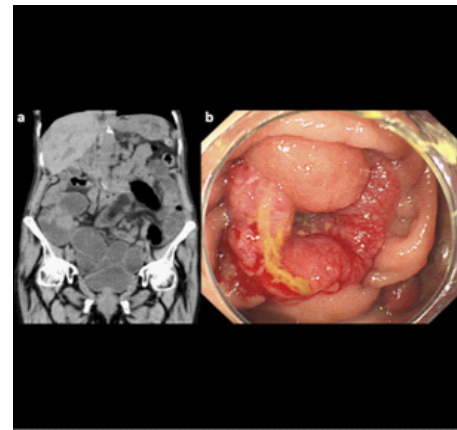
Abdominal computed tomography revealed thickened ileocecal stenosis and dilation of the ileum (a). The ileocecal valve was infiltrated by the tumor, excluded, and narrowed. The endoscope could not pass through the valve (b).
